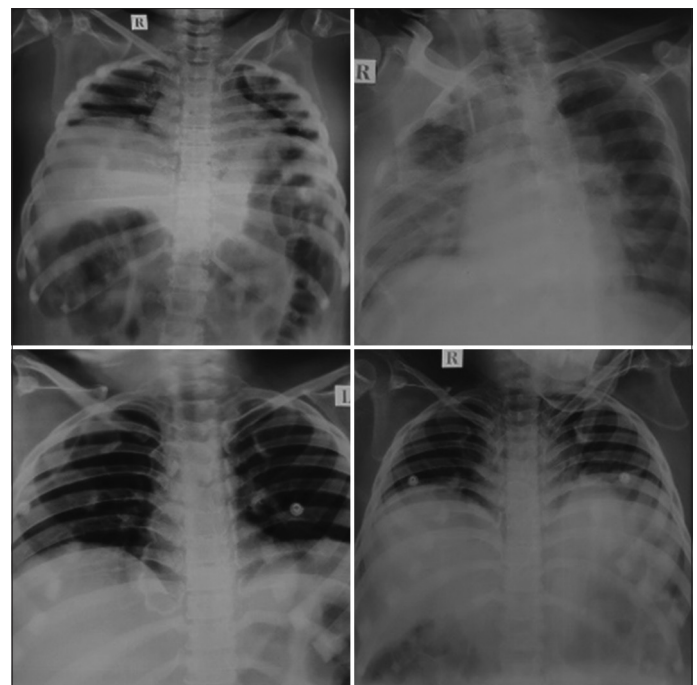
Serial X-rays taken on 1st, 3rd, 5th, and 7th days of intensive care unit stay
